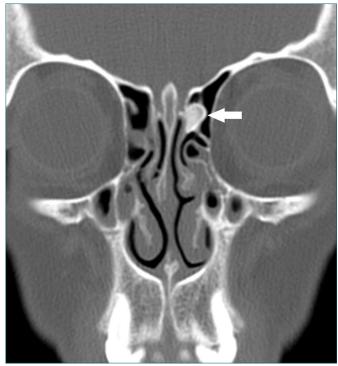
Coronal section CT image, showing anterior ethmoidal sinus osteom (white arrow).
